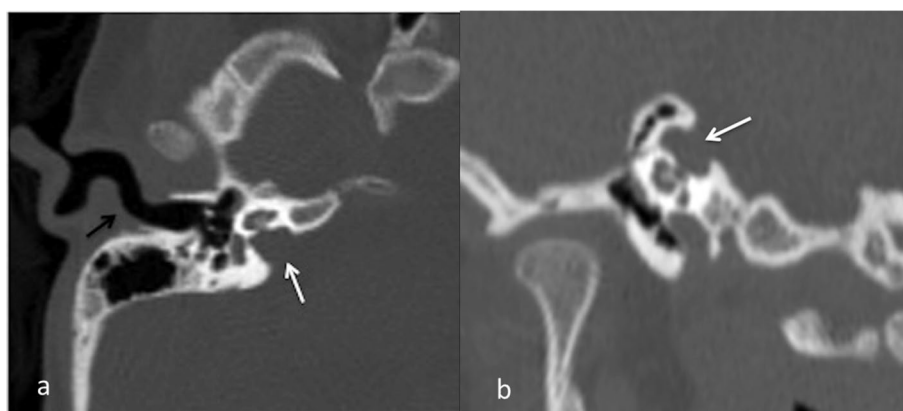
Axial (a) and coronal (b) oblique reformatted CT image shows right IAC (white arrows) and right EAC (black arrow)
